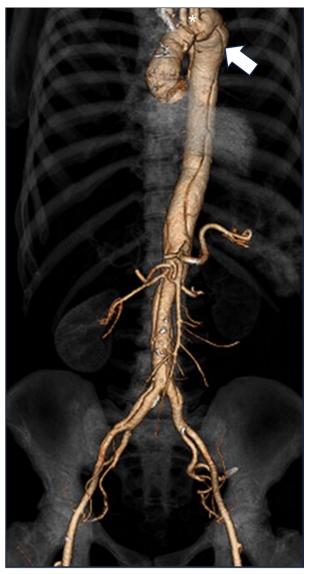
Post-procedure three-dimensional computed tomography scan of chest, abdomen, and pelvis. Postprocedural changes of the aortic root and unchanged aortic dissection extending into the left subclavian artery (star), to the descending thoracic and abdominal aorta, as well as to both common iliac arteries, with a maximum diameter of 4.3 cm at the level of the proximal descending thoracic aorta (arrow).
